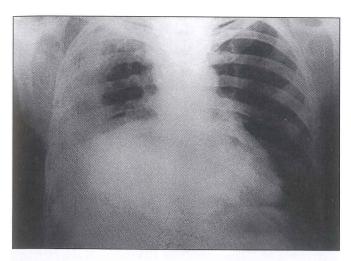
Chest X-ray of the patient three years after the first diagnosis of GCTB
